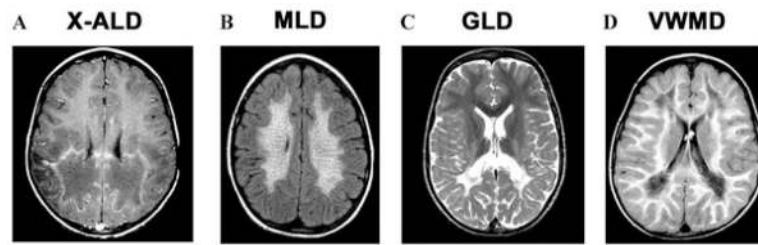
MRI appearance of (A) X-linked adrenoleukodystrophy (X-ALD), T1-weighted image post-gadolinium; (B) metachromatic leukodystrophy (MLD), FLAIR image; (C) globoid cell leukodystrophy (GLD), T2-weighted image; and (D) vanishing white matter disease (VWMD), T1-weighted image.
